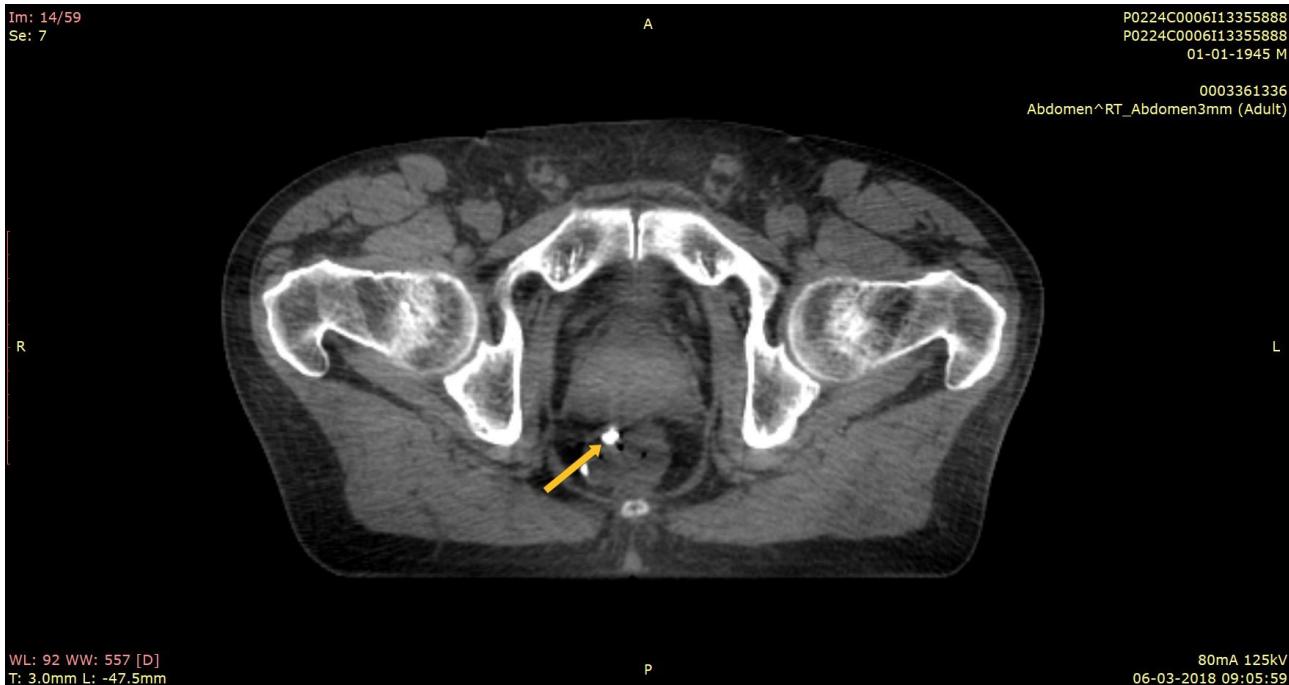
CBCT showing BioXmark® in the rectal wall of patient with rectal adenocarcinoma.
